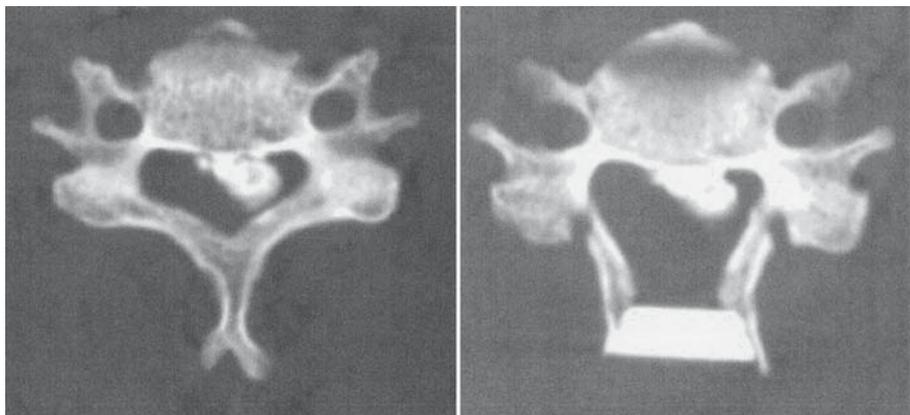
Preoperative and postoperative computed tomography
